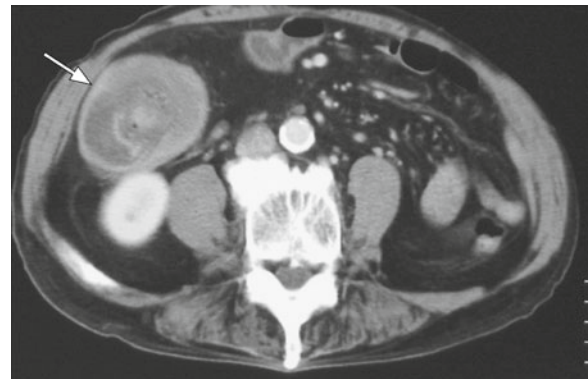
Contrast-enhanced CT. The interior of the lesion exhibited a stratified enhancing effect, and the lesion in the terminal part of the ileum had caused intestinal intussusception
